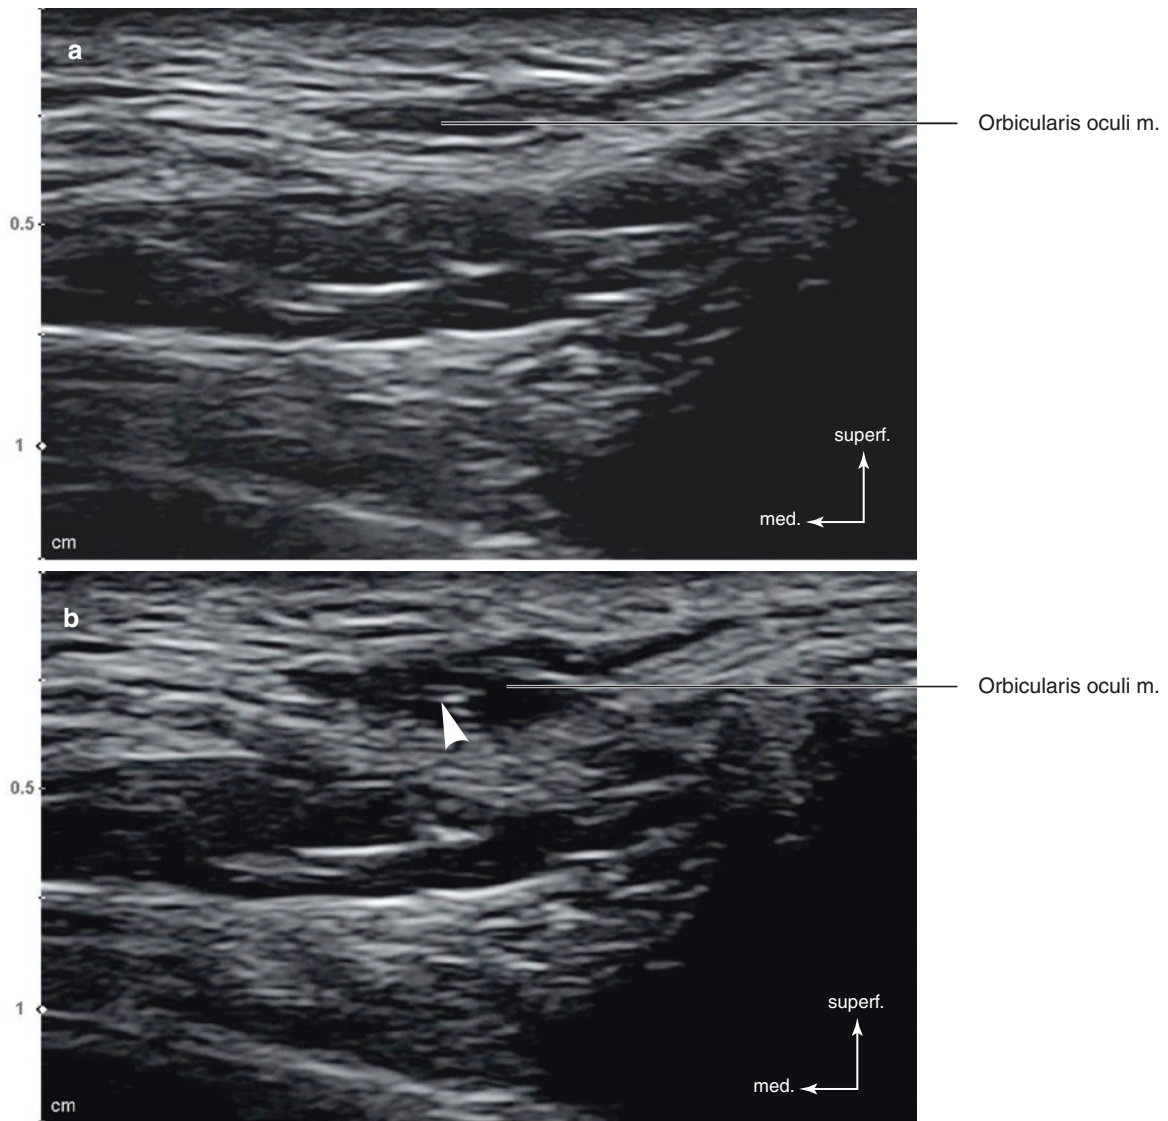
Ultrasonography-guided botulinum toxin injection to the orbicularis oculi muscle. (a) Before injection, B mode (transverse view, 15 MHz by linear transducer) and (b) during injection (out-of-plane), B
